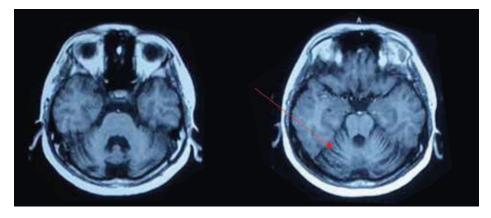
MRI brain T1-weighted axial images showing cerebellar atrophy with prominent folia(arrow).
